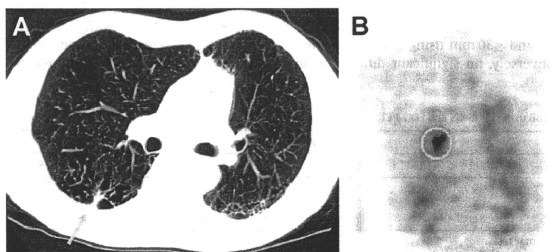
Images from a 74-year-old man with COPD and squamous cell carcinoma of the lung showing positive findings on FDG-PET. (A) On chest CT, a small PPL 15 mm in mean diameter is seen in segment 6 of the right lung. (B) On FDG-PET, coronal scan demonstrates higher FDG uptake in the right lower lobe (SUV_{max} , 4.52).
